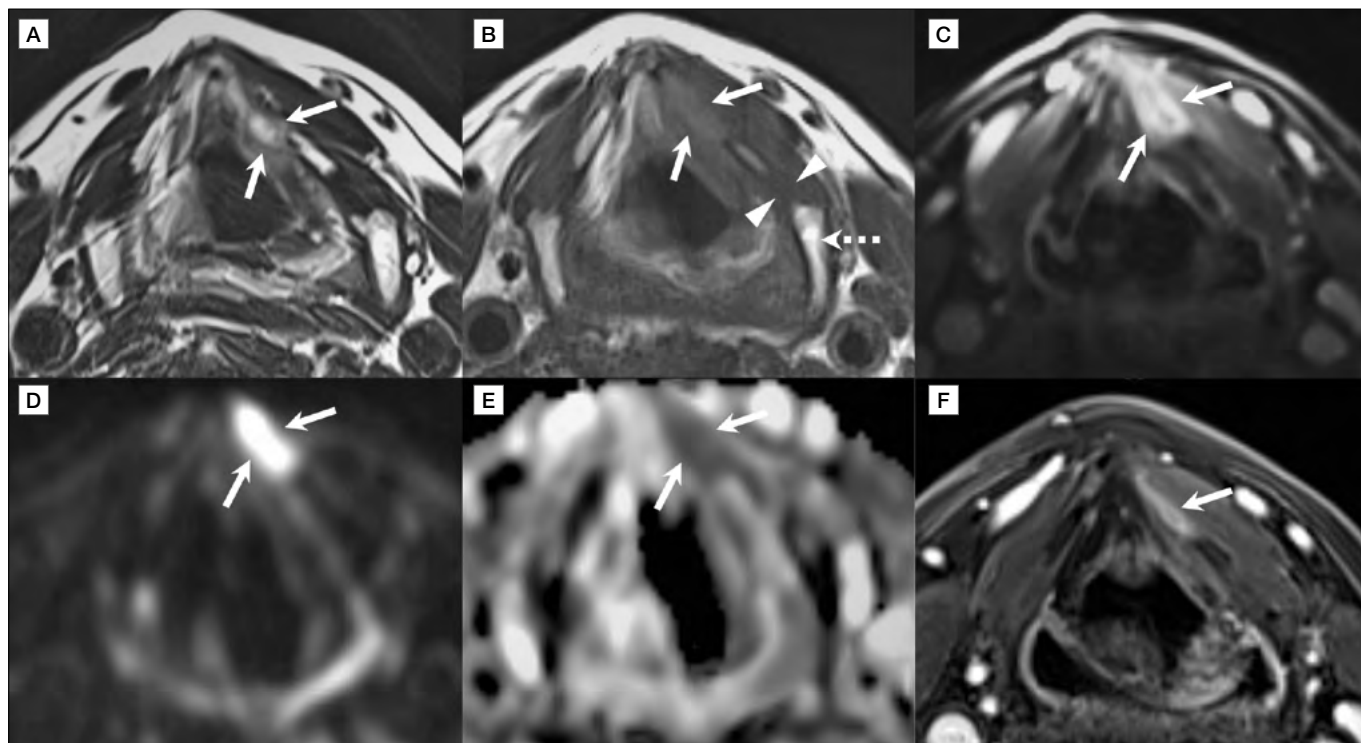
Focal post- CO_2 TOLMS LC in patient No. 6. Axial images at the supraglottic level: TSE T2-weighted (A), T1-weighted (B), contrast-enhanced fat-saturated T1 (VIBE) (C), DWI b900 (D) and ADC map (E). Focal lesion (arrows) involving the anterior residual left false vocal cord and the full thickness of the adjacent segment of the thyroid lamina. It is characterised by T2-weighted hyperintensity and T1-weighted hypointensity compared to ossified cartilage (dotted arrow in B), while it shows T1-weighted slightly hyperintense signal compared with non-ossified cartilage (arrowheads in B). There is intense peripheral contrast enhancement (arrows in C) and minimal diffusion restriction pattern (hyperintense signal on DWI and corresponding hypointense signal at the ADC map; mean ADC value of $1.2 \times 10^{-3} \text{ mm}^2/\text{s}$). Axial contrast-enhanced fat-saturated T1 (VIBE) at 2 months follow-up (F) shows marked improvement of the LC process, with size reduction and decreased contrast enhancement of the focal lesion (arrow in F).
